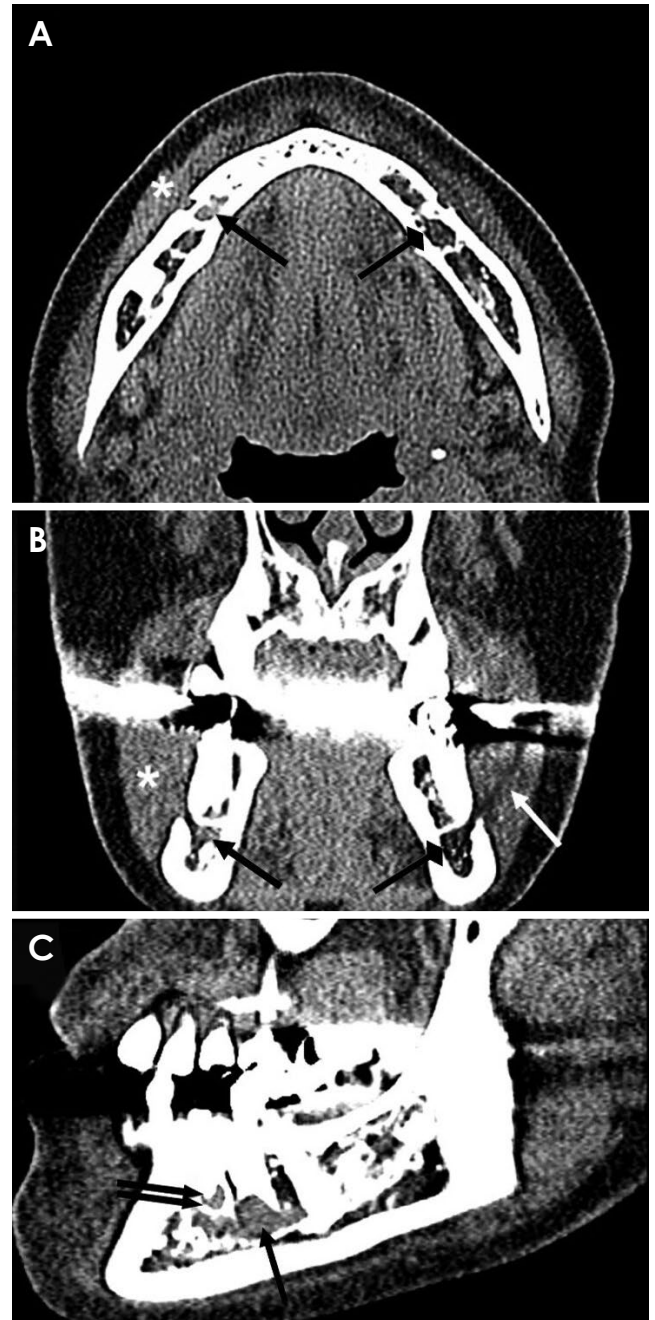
A and B. Soft tissue window multislice computed tomography (MSCT) images reveal increased attenuation (arrow) in the bone marrow space beneath the right mandibular second premolar. The normal bone marrow space below the left mandibular premolar exhibits fatty attenuation (diamond arrow). Note the increased attenuation and obliteration of the fat plane (asterisks) on the buccal side of the right mental foramen, suggesting the spread of inflammation from the bone marrow space. The fat plane (white arrow) between the buccal facial muscles is preserved on the buccal side of the left mental foramen. C. A parasagittal MSCT image with a soft tissue window shows the periapical lesion (double arrow) and increased attenuation (arrow), indicative of inflammatory changes, in the bone marrow space beneath the right mandibular second premolar.
